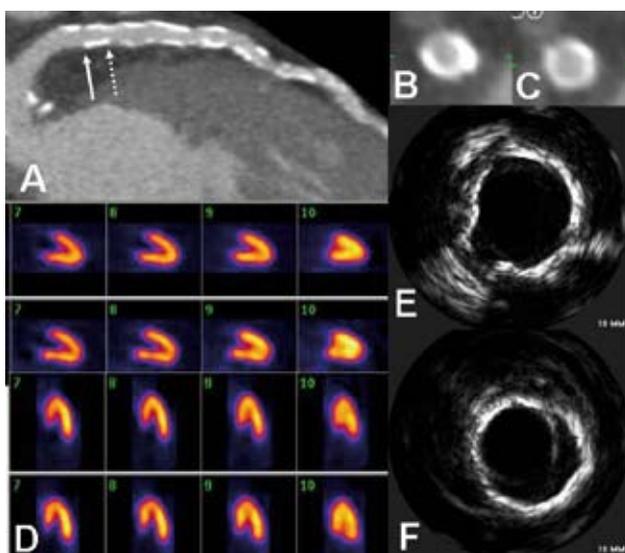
A 60-year old male presented to the outpatient clinic with dyspnea and an elevated risk profile for coronary artery disease, including hypertension, hypercholesterolemia and smoking. Contrast enhanced MSCT coronary angiography revealed considerable atherosclerosis in the left anterior descending coronary artery (Panel A). Panels B and C are cross-sectional images of the areas indicated by the arrows in Panel A. In contrast, myocardial perfusion imaging (Panel D), which was performed during exercise stress (first and third panel) and rest (second and fourth panel), showed normal perfusion. However, also during intravascular ultrasound imaging (Panels E and F), considerable plaque burden was demonstrated, yet with preservation the coronary lumen.
